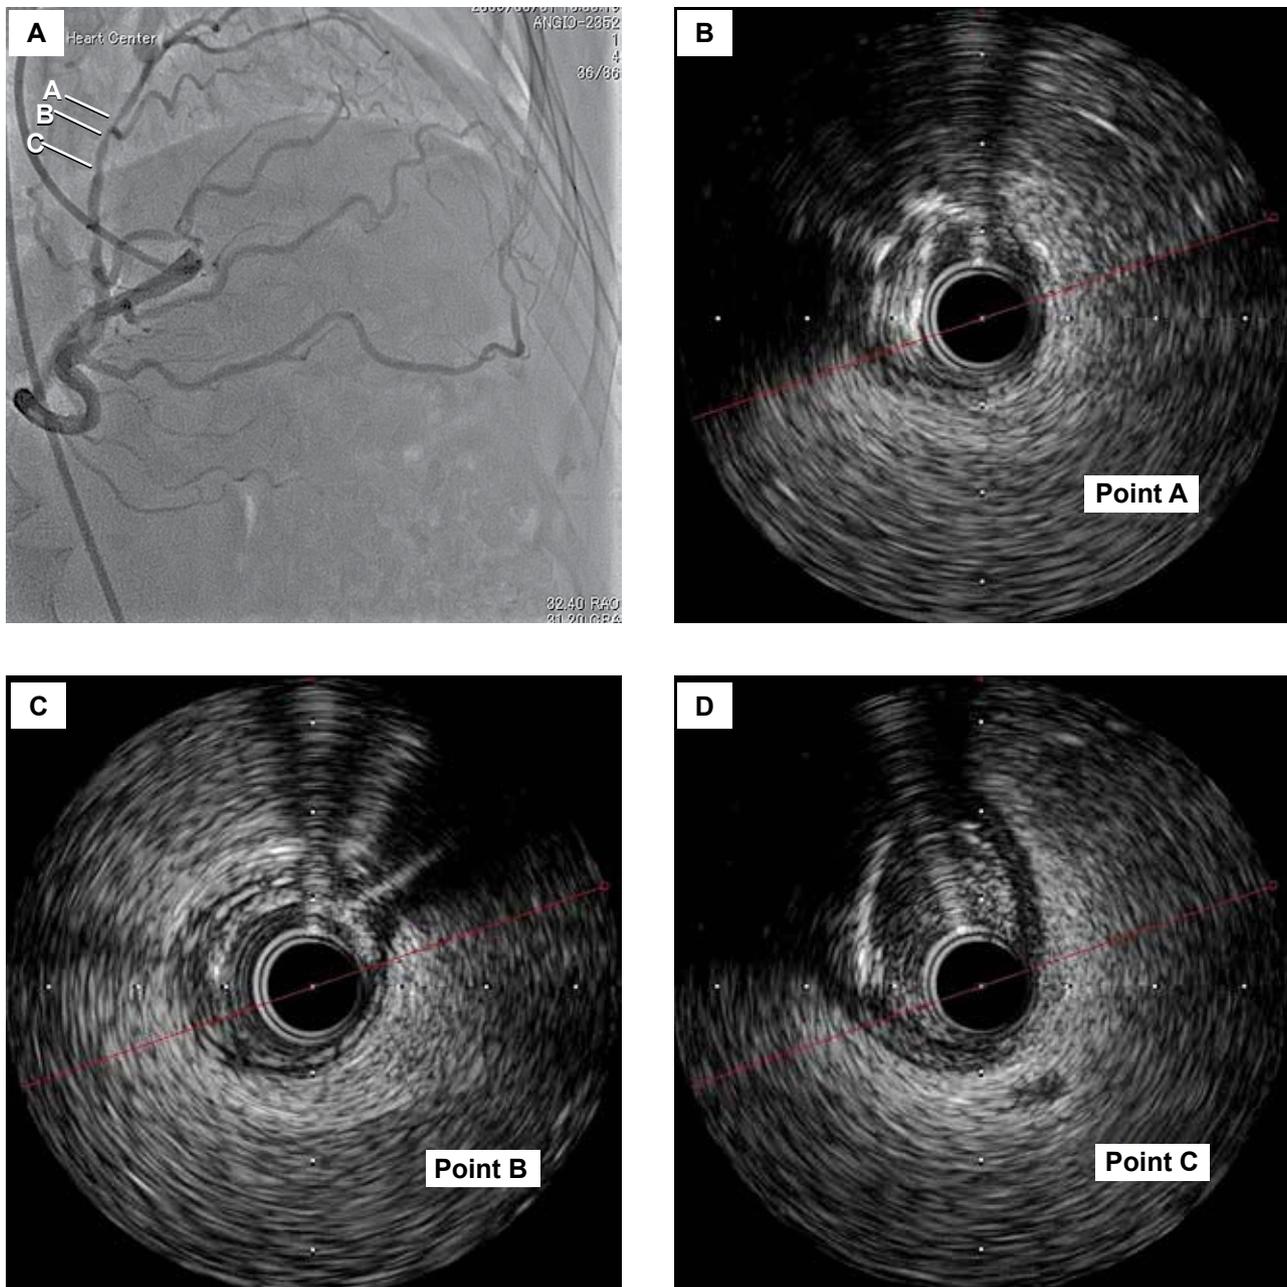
Intravascular ultrasound images showing eccentric calcified plaque located at the distal lesion (Point A); eccentric fibrous plaque located at the middle lesion (Point B); eccentric soft plaque located at the proximal lesion (Point C).
